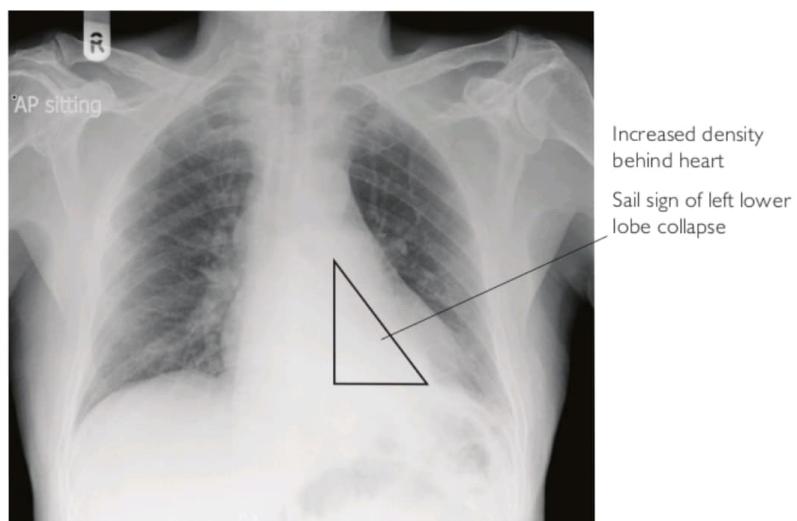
Sail sign of left lower lobe collapse (identified on the chest x-ray, investigated by CT)
